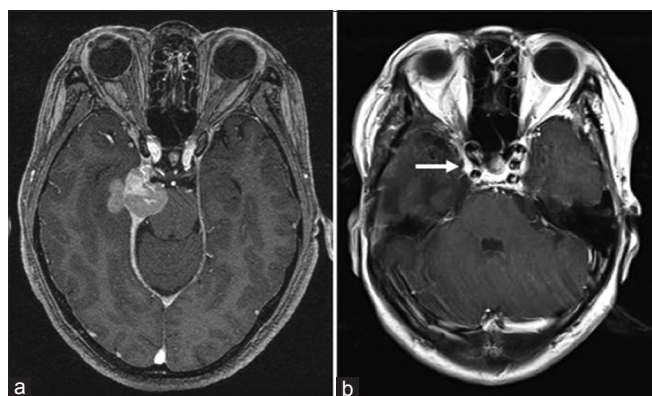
Magnetic resonance images from the original patient presentation in 2007. (a) Preoperatively, axial T1-weighted contrast images demonstrated a mass lesion located along the right tentorium, extending toward the temporal lobe and the pons. (b) Postoperative T1-weighted contrast image. A tumor invading into the cavernous sinus (arrow) remained. The extent of resection was judged as "subtotal"
